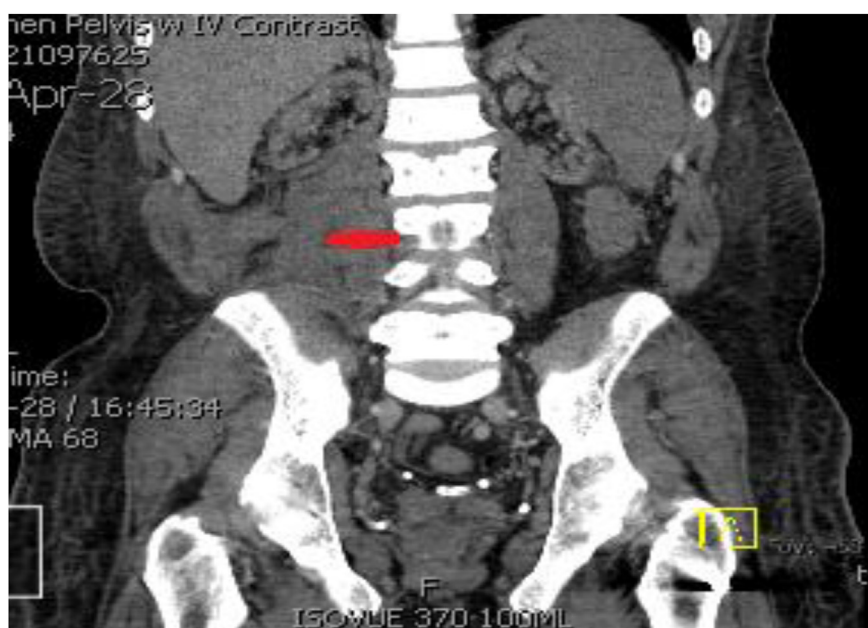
CT abdomen and Pelvis w Iv contrast -Right retroperitoneal hematoma extending into retroperitoneal pelvis.
